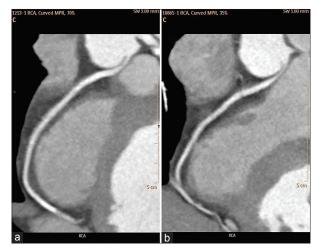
Computed tomographic coronary angiogram in global image showing (a) diastolic frame (taken at 70% of RR interval) good right coronary artery caliber. In end, systolic frame (b) taken at 35% of RR interval the right coronary artery seen significantly compressed at origin in it is inter-arterial course
